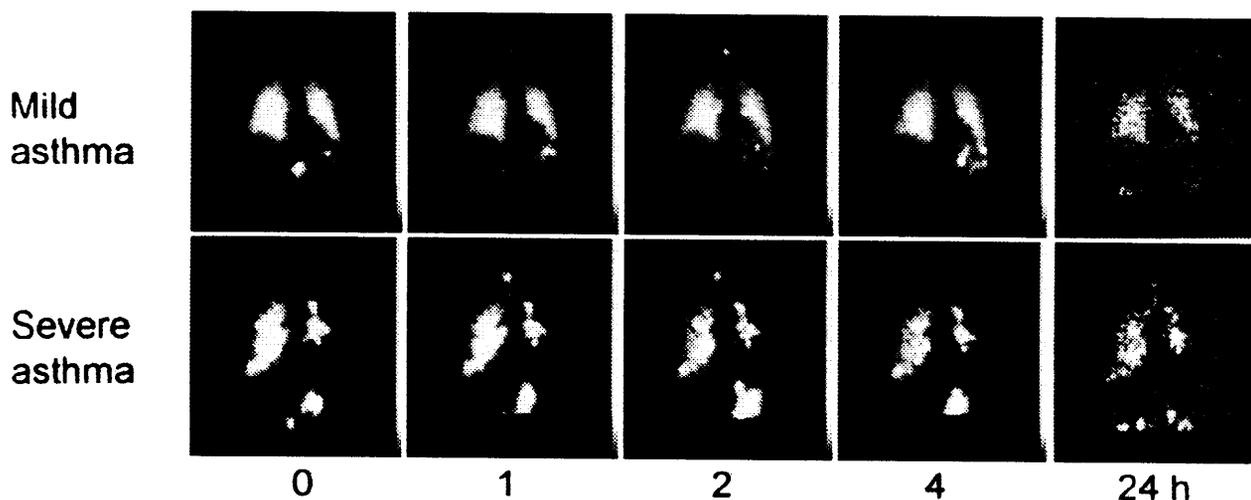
Anterior chest scintigraphs of a patient with mild asthma and a patient with severe asthma at 0, 1, 2, 4, and 24 h following ^{99m}Tc -labeled Bec-DLPC liposome aerosol. The images are corrected for background and physical decay.
